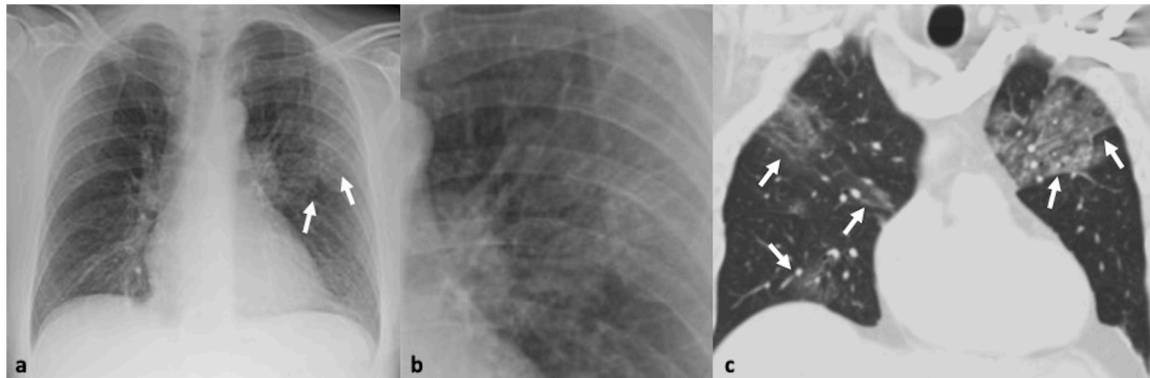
41-year-old male with confirmed influenza pneumonia who presented with fever, dry cough and myalgia. 1a, b. Chest x-ray and magnified view shows left upper lobe patchy increased air-space opacification (arrows). 1c. Coronal CT image confirms the left upper lobe ground glass opacity and further multifocal ground glass involvement in both lungs (arrows).
